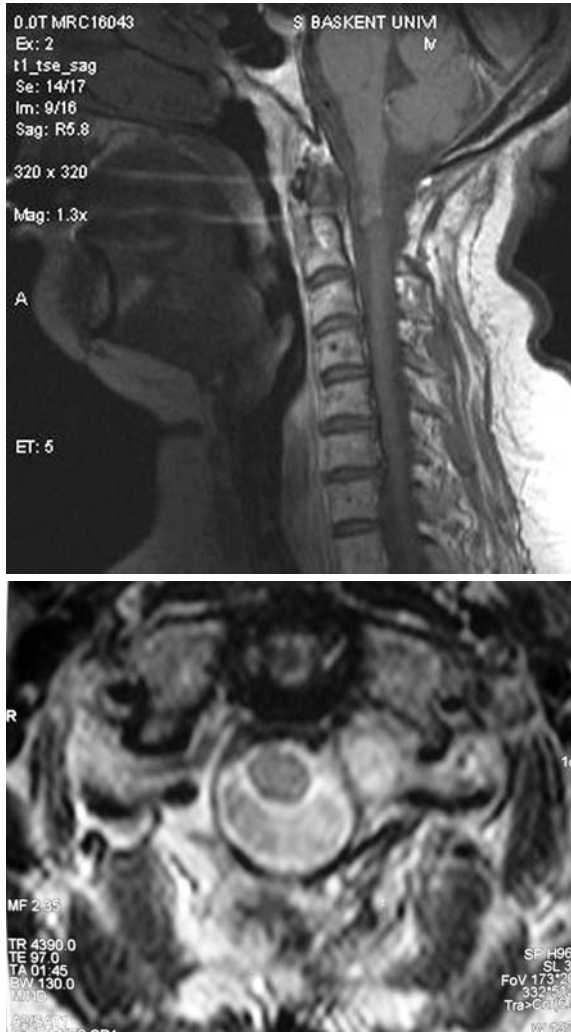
Sagittal (A) and axial (B) T2-weighted MR images of the cervical spine of the patient taken 2 months after the operation clearly show that the intradural component of the tumor at the level of C1-C2 was excised and there was no spinal cord compression.
